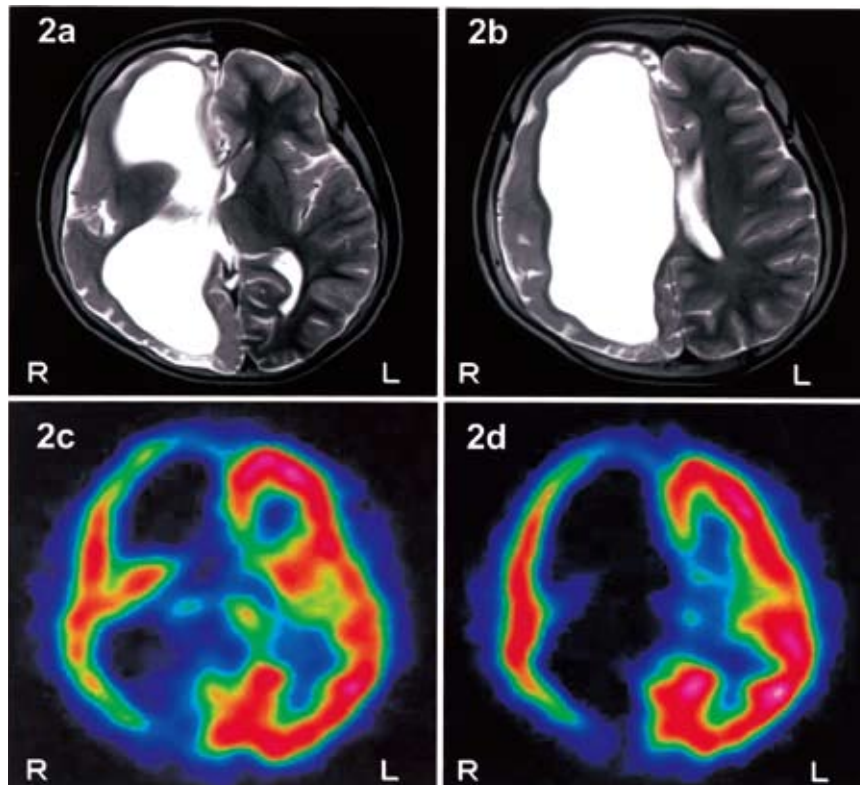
Magnetic resonance imaging (2a, 2b) and ^{99m}Tc -ECD Single photon emission computed tomography : SPECT (2c, 2d)
